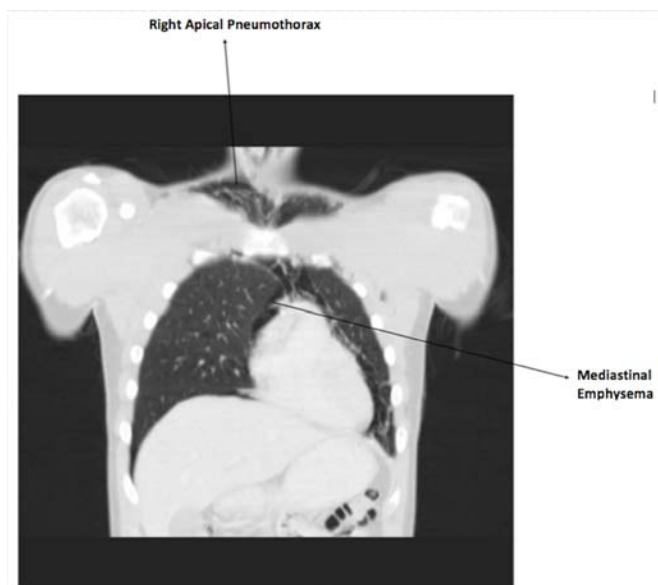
CT of the thorax showing pneumothorax and mediastinal emphysema.
